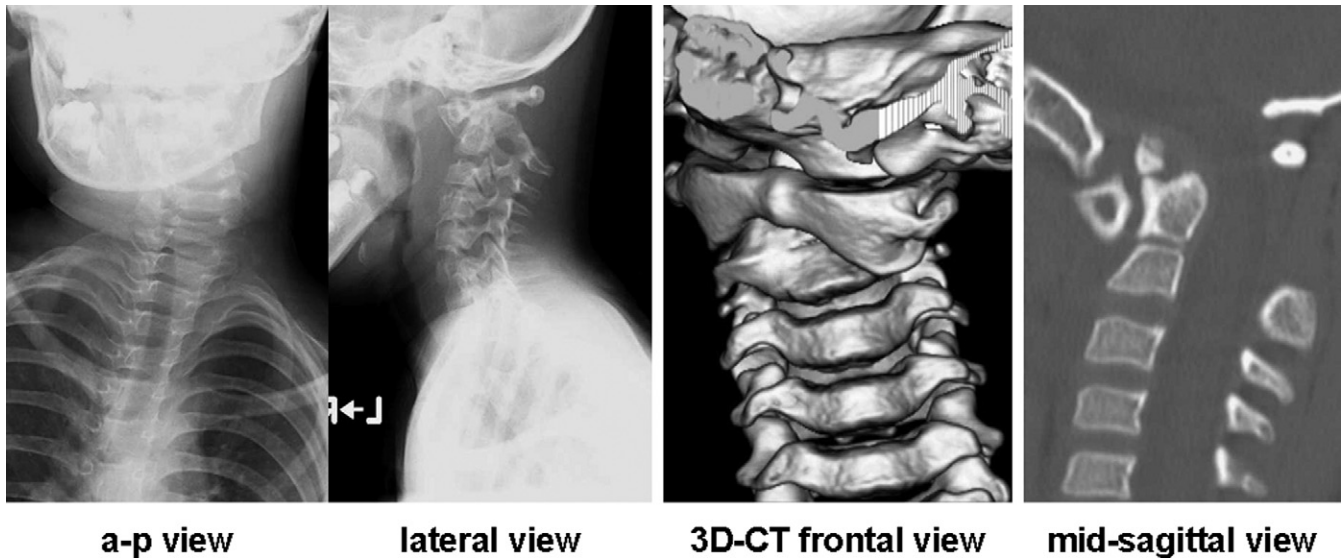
Preoperative X-ray and CT scan in case 1. On plain radiographs, the cervical spine showed malalignment at the atlantoaxial level with torticollar deformity. Plain CT showed not only sagittal but also axial dislocation of the atlantoaxial joint with os odontoideum. (a-p, anteroposterior; 3D, 3-dimensional.)
